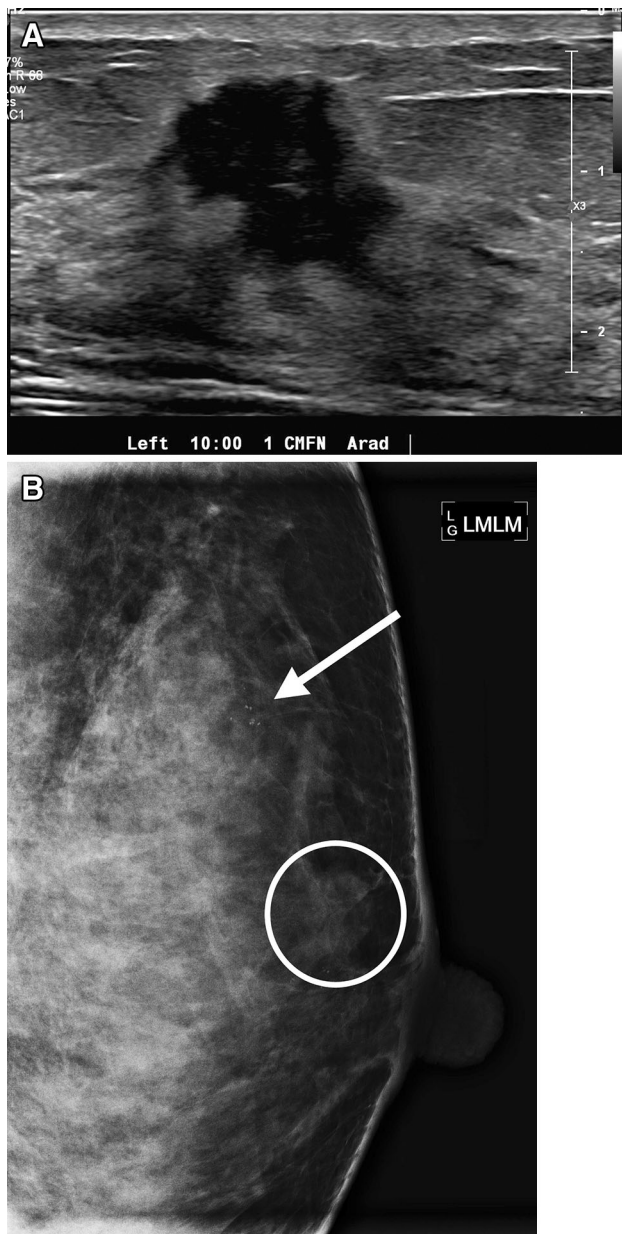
A 33-year-old pregnant female with a palpable left retroareolar lump. a Targeted ultrasound shows a hypoechoic irregular mass with speculated margins. Given the highly suspicious sonographic finding, decision was made to pursue diagnostic mammography. b Left breast diagnostic mammogram shows the obscured mass (circle) corresponding to the sonographic mass. In addition, a group of fine pleomorphic calcifications were identified remote from the palpable mass. Ultrasound-guided core biopsy of the mass revealed invasive ductal carcinoma and stereotactic core biopsy of the calcifications revealed high-grade DCIS
